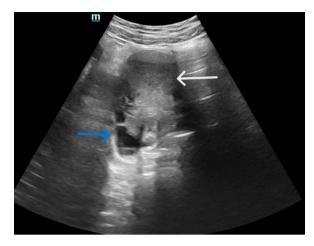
Pelvic ultrasound – Blue arrow denote ovary and white arrow denote ovarian mass.
